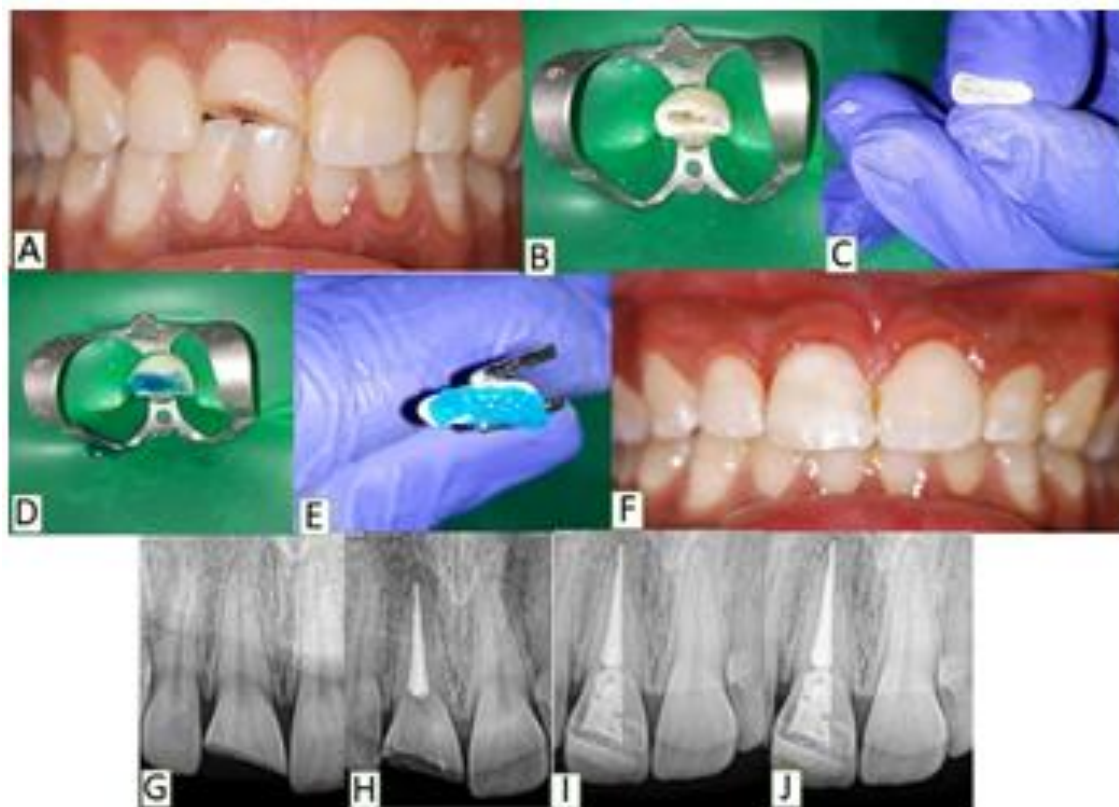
Case Report 1: (A) Pre-operative clinical picture. (B) Rubber dam isolation. (C) Groove made in fractured tooth segment. (D-E) Etching of tooth and segment. (F) Post-operative clinical picture after fragment reattachment. (G) Pre-operative radiograph. (H) Radiograph after single sitting root canal treatment. (I) Post-operative radiograph. (J) Radiograph at 1 year follow up.
